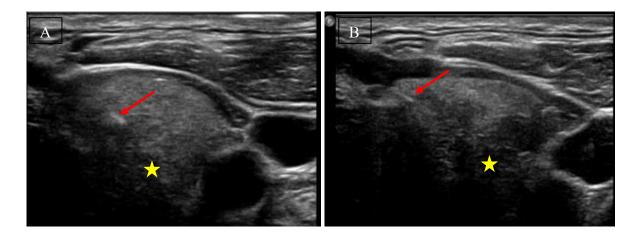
Transverse sections of a cervical ultrasound in A and B.
